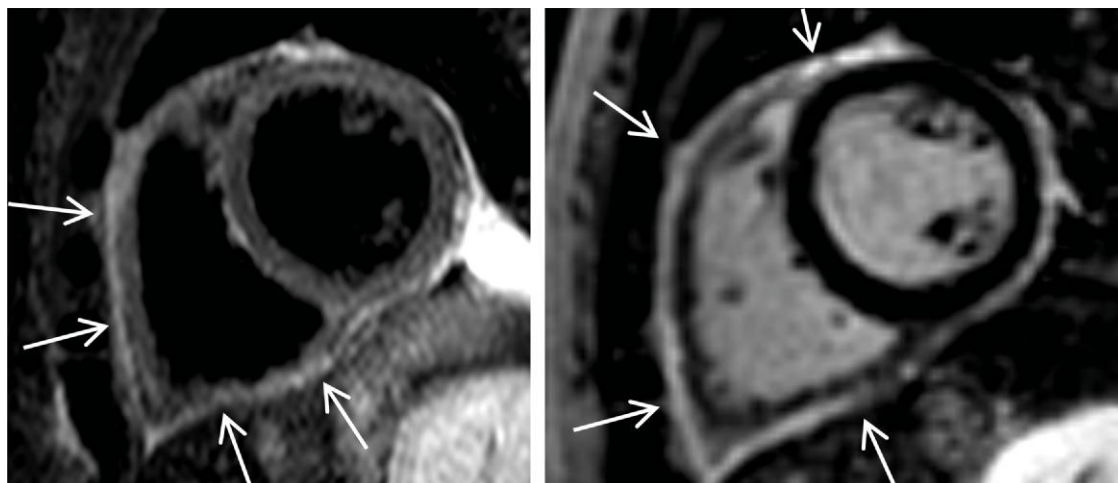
Cardiac magnetic resonance imaging. Left, short-tau inversion recovery images; right, late gadolinium enhancement images. Arrows indicate the thickened pericardium.
